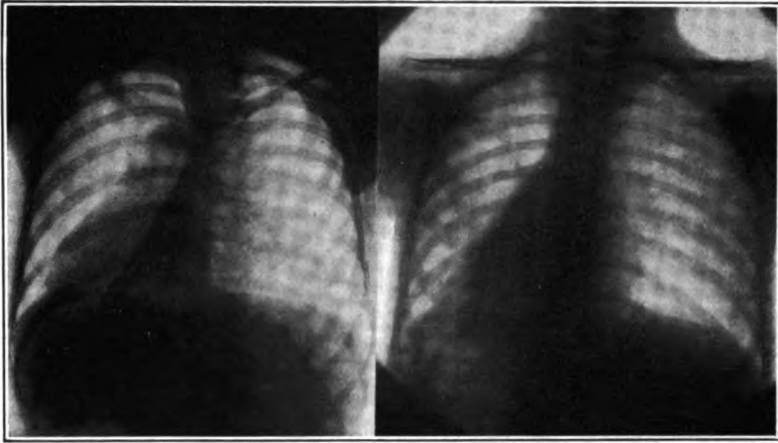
Roentgenogram showing obstruction of the left inferior lobe bronchus, by a Greek peanut (pistachio) shell, in a girl of 8 years. When such a shadow is seen we may know that we shall have to deal with a foreign body fitting tightly and corklike in a bronchus. There is shown compensatory emphysema of the right lung and also of the left upper lobe. The right-hand roentgenogram shows the disappearance of the triangular shadow after the removal of the pus and the obstructing foreign body, by bronchoscopy, without anesthesia, general or local. (Plate made by Drs. Johnston and Grier. Author's case.)
